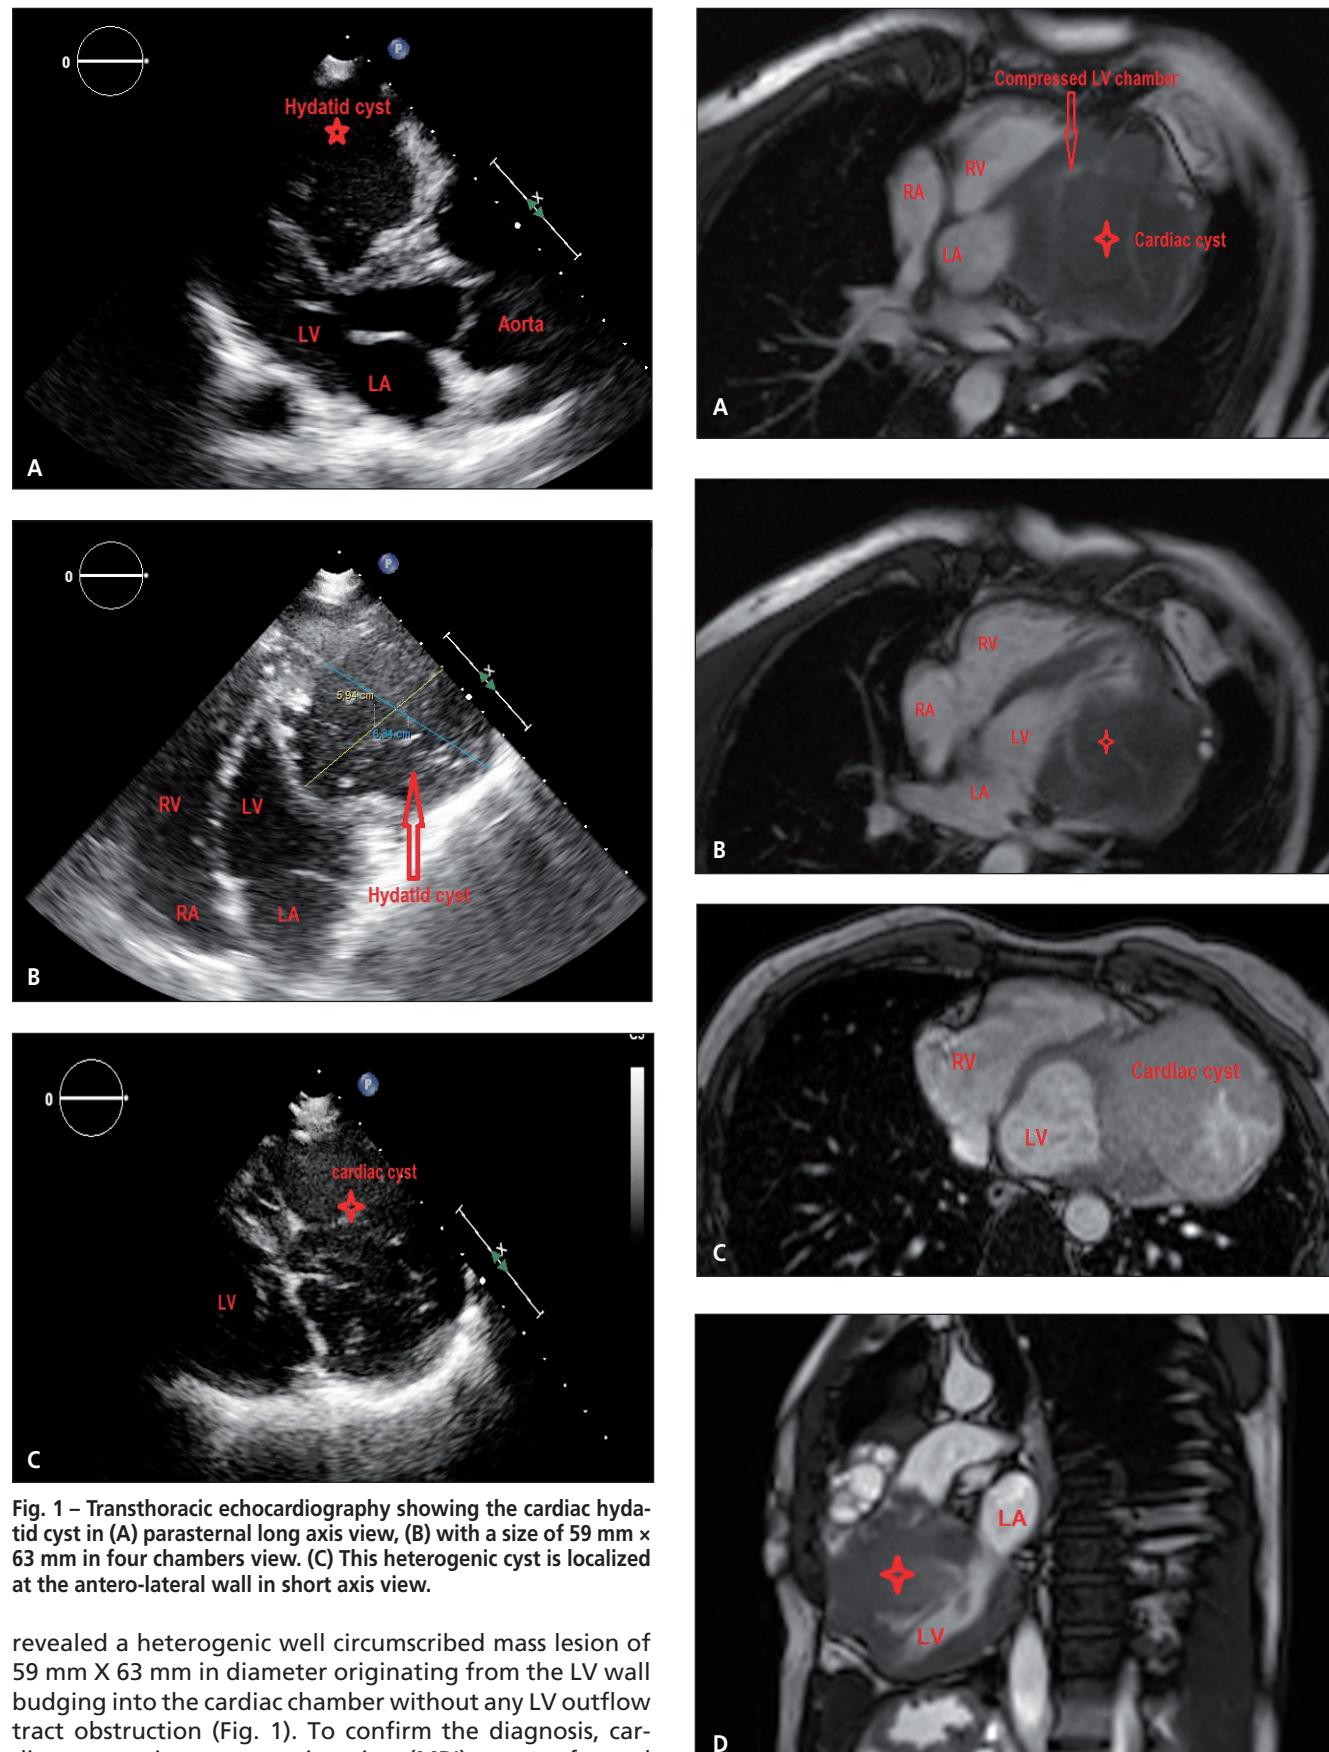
Transthoracic echocardiography showing the cardiac hydatid cyst in (A) parasternal long axis view, (B) with a size of 59 mm x 63 mm in four chambers view. (C) This heterogenic cyst is localized at the antero-lateral wall in short axis view.
